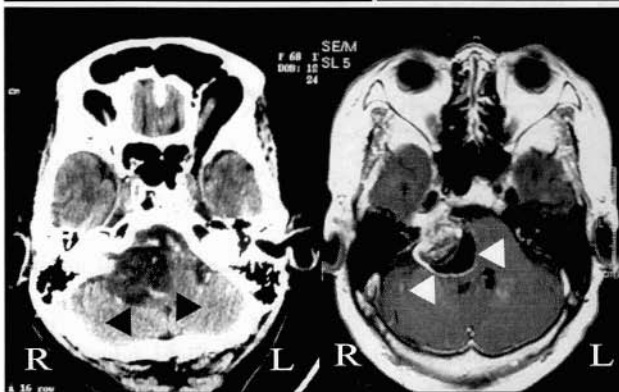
Right vestibular schwannoma. *Left:* CT scan - hypodense mass at CPA (black arrowheads) with mild contrast enhancement. *Right:* T1-weighted MRI - the same mass (white arrowheads) with rim enhancement.
